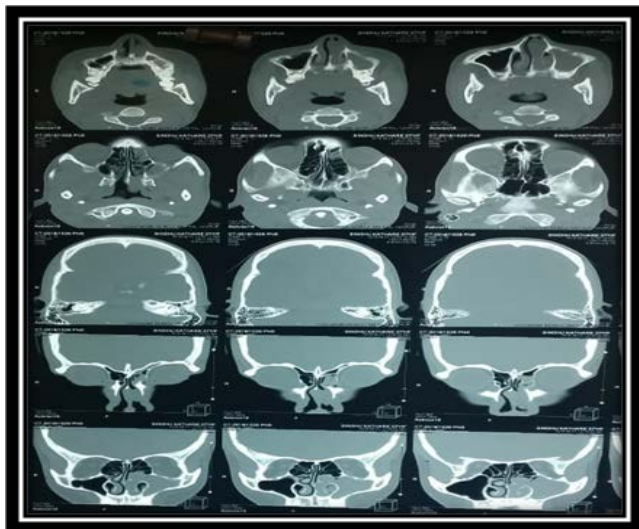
CT image shows opacity in the right sided nasal cavity(arrow).
